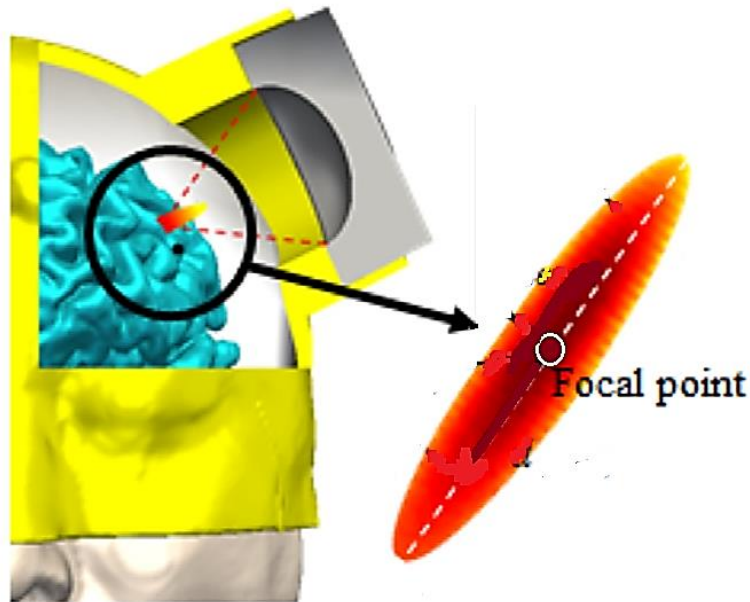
3D cross sectional view of ultrasound stimulation (Joe et al., 2019)
